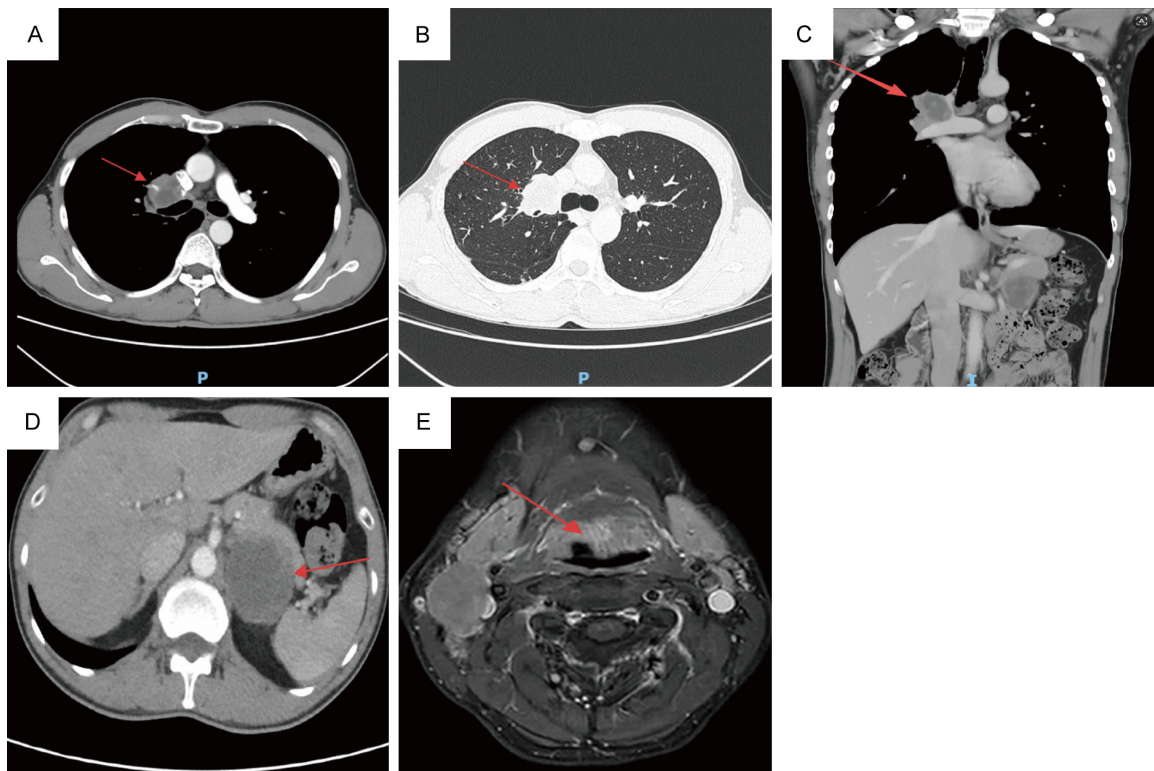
Response evaluation during the clinical course. A-C. The pretreatment chest CT revealed an irregular soft tissue mass in the right upper hilum, measuring approximately $3.2 \times 3.4 \times 3.7$ cm. The mass exhibited ill-defined margins, lobulation, spiculation, and heterogeneous enhancement, with encasement of the right upper lobar pulmonary artery. D. A pretreatment abdominal CT image demonstrates a round-like mass in the left adrenal gland, measuring approximately 5.3 cm $\times$ 5.3 cm $\times$ 6.4 cm. The mass exhibits a relatively well-defined margin and shows heterogeneous mild enhancement at the periphery on contrast-enhanced scans (arrow). E. Pretreatment oropharyngeal and neck MRI demonstrated a focal depression on the right tongue base (estimated $3.5 \times 1.9 \times 1.9$ cm; arrow) along with multiple bilateral cervical lymph nodes, some of which were necrotic and the largest measuring $3.4 \times 2.0 \times 3.2$ cm.
